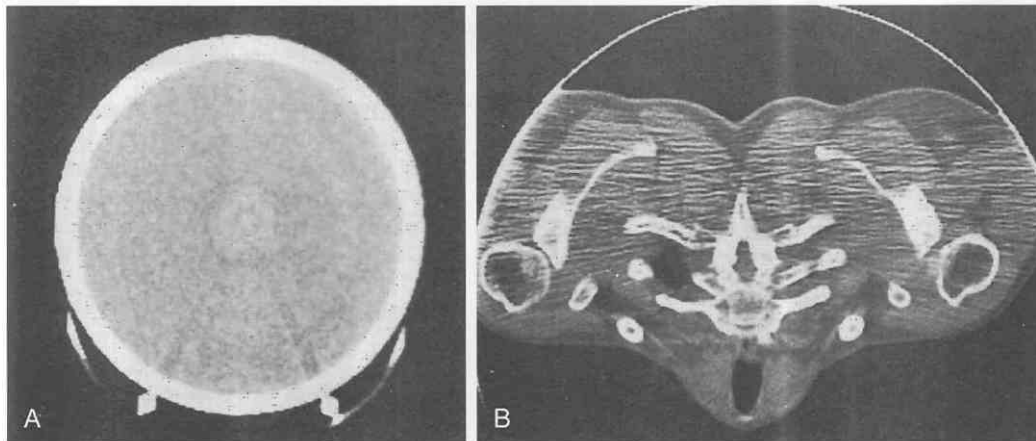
Examples of CT image artifacts. *A*, Ring artifact obtained with a third-generation CT scanner. *B*, Streak artifacts.
